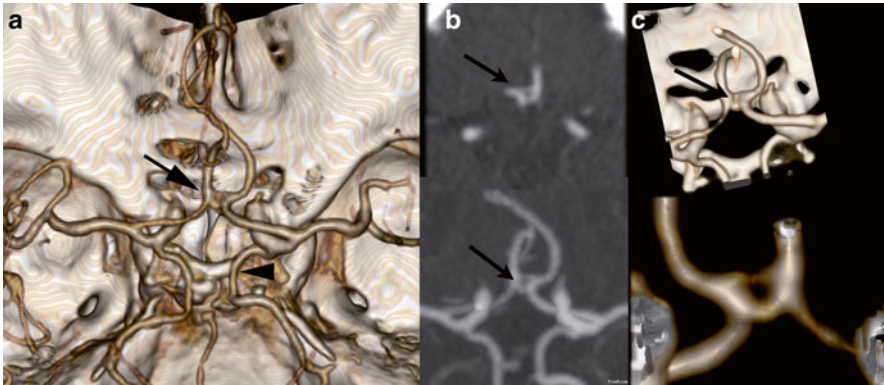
An 80 y/o male presented with ischemic stroke in the left hemisphere. No occlusions were found at CTA. Two normal variants were present. The fenestration of the Acom (arrows) is demonstrated at CTA of the circle of Willis (a), at the CTA source images (b), MIP reconstructions (c), and detailed volume rendering without (d) and with bone removal (e). The arrowhead points out bilateral fetal configuration of posterior cerebral artery (a)
